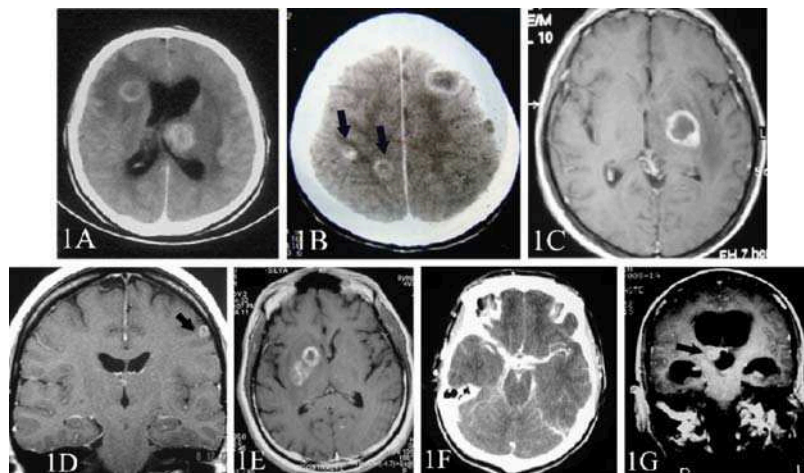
(a) CT scan showing typical hypodense, ring-enhanced lesions of cerebral toxoplasmosis in right anterior limb of internal capsule and left thalamus; (b) CT scan showing cystic lesions of neurocysticercosis at cortical–subcortical junction with ring-enhancement. A nodular enhancement inside the cyst corresponding to the scolex is seen in two lesions (*arrows*); (c) axial gadolinium-enhanced T1-weighted MRI scan showing left parietal lesion with mild mass effect, perilesional edema, and ring-enhancement in AIDS patient with cerebral Chagas' disease (*Courtesy of Dr. Marcelo Corti, HIV/AIDS Division, Infectious Diseases F. J. Muñiz Hospital, Buenos Aires*); (d) gadolinium-enhanced T1-weighted MRI scan showing cryptococcoma (*arrow*) and mild meningeal enhancement in a patient with cryptococcal meningitis; (e) axial gadolinium-enhanced T1-weighted MRI scan showing two contiguous lesions in right parietal lobe in a man with cerebral paracoccidioidomycosis; (f) CT scan showing gross meningeal enhancement in a patient with tuberculous meningitis; (g) coronal gadolinium-enhanced T1-weighted MRI scan showing a tuberculoma (*arrow*) and hydrocephalus in a AIDS patients with neurotuberculosis
